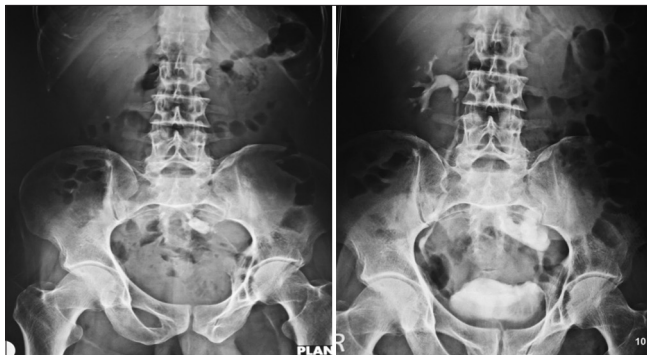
Kidney, ureter, bladder X-ray and intravenous pyelogram
